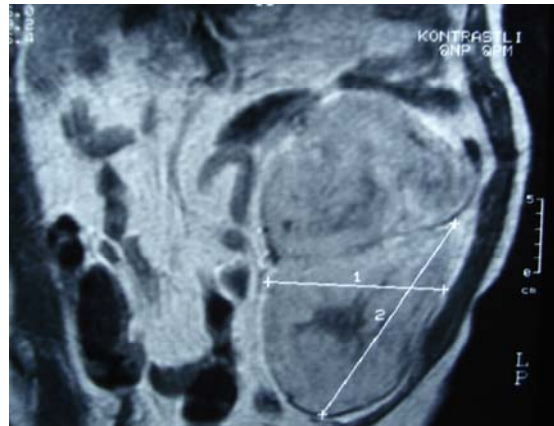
MRI scan shows masses arising in the left retroperitoneum before third operation
